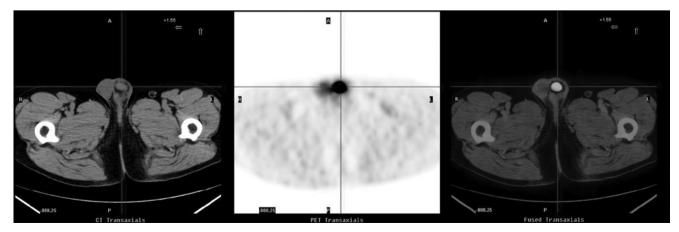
First <sup>18</sup>F-FDG PET/CT scan. High uptake of tracer in the left testicle with max SUV 21.0.
